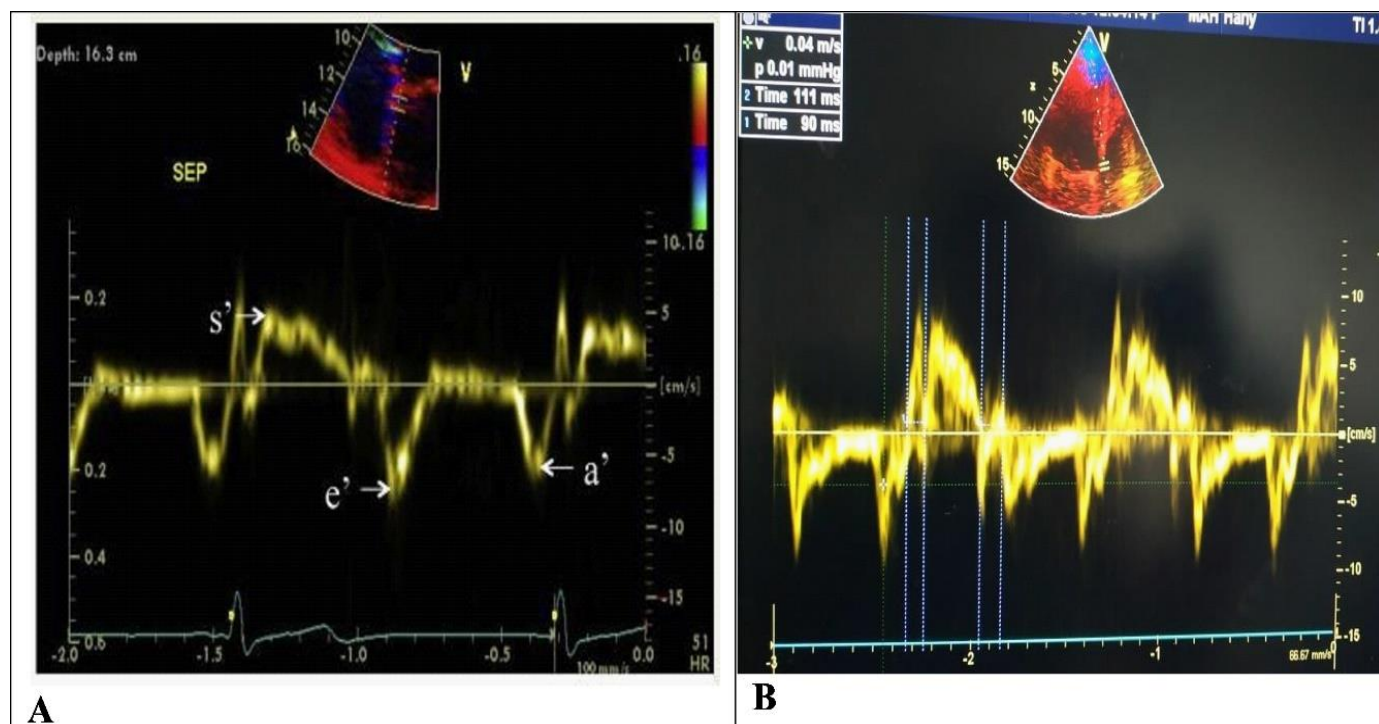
(A): Pulsed wave tissue Doppler imaging from apical 4 chamber view sampling from septal mitral annulus [4] and (B): An image of the echocardiographic study of one of our studied cases.
